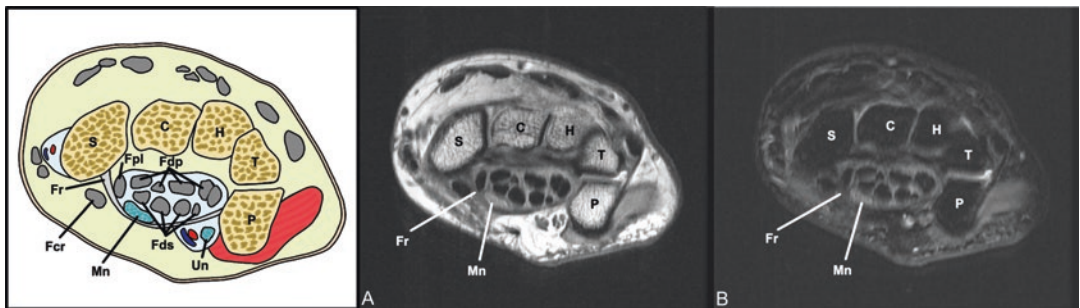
Axial MRI proton density (a) and T2 fat saturation (b)—normal anatomy at the level of the pisiform; S scaphoid, C capitate, H hamate, T triquetrum, P pisiform, Mn median nerve, Un ulnar nerve, Fdp flexor digitorum
